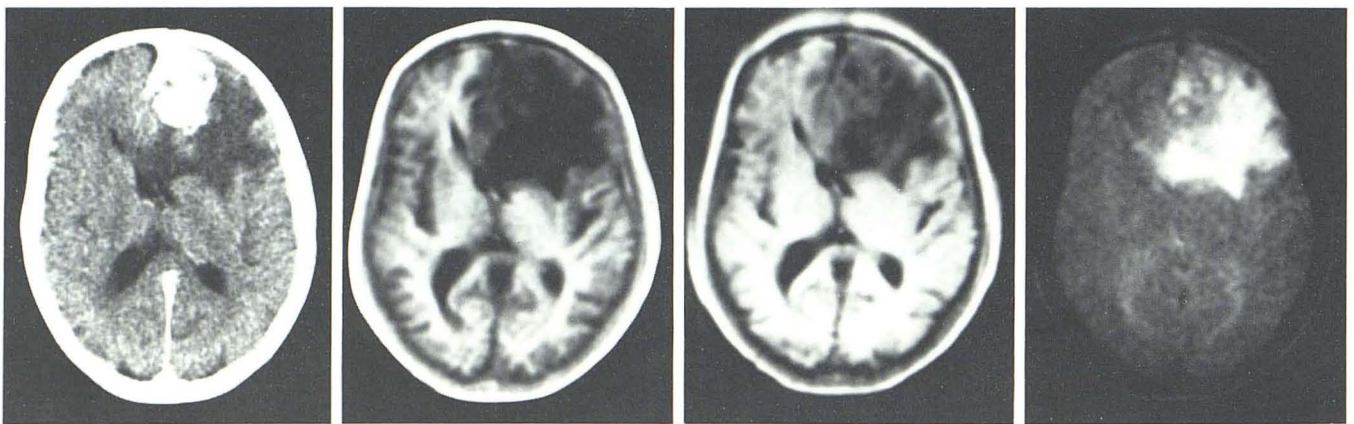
Metastasis from nasopharyngeal carcinoma. A, Contrast-enhanced CT. B, IR_{1400/400}. C, IR_{2400/800}. D, SE_{1080/40}. Margin between tumor and surrounding edema poorly defined in B, although it is slightly clearer in C. Cerebral edema better defined in D.
